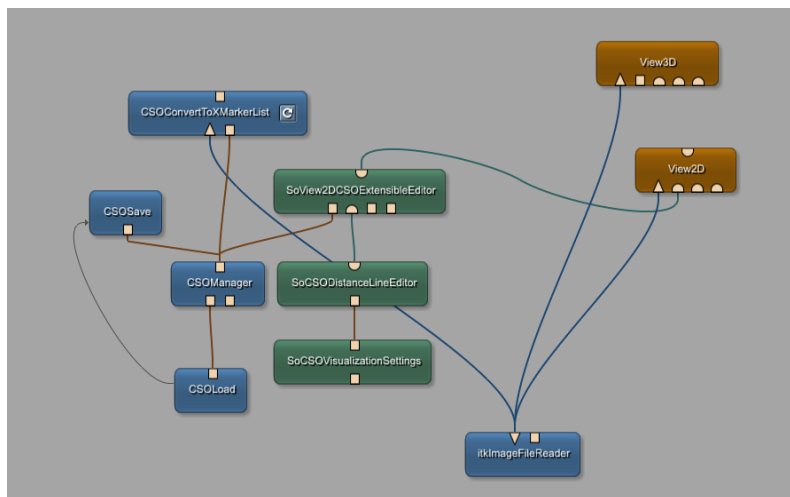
MeVisLab network for inspecting and annotation brain CT scans
